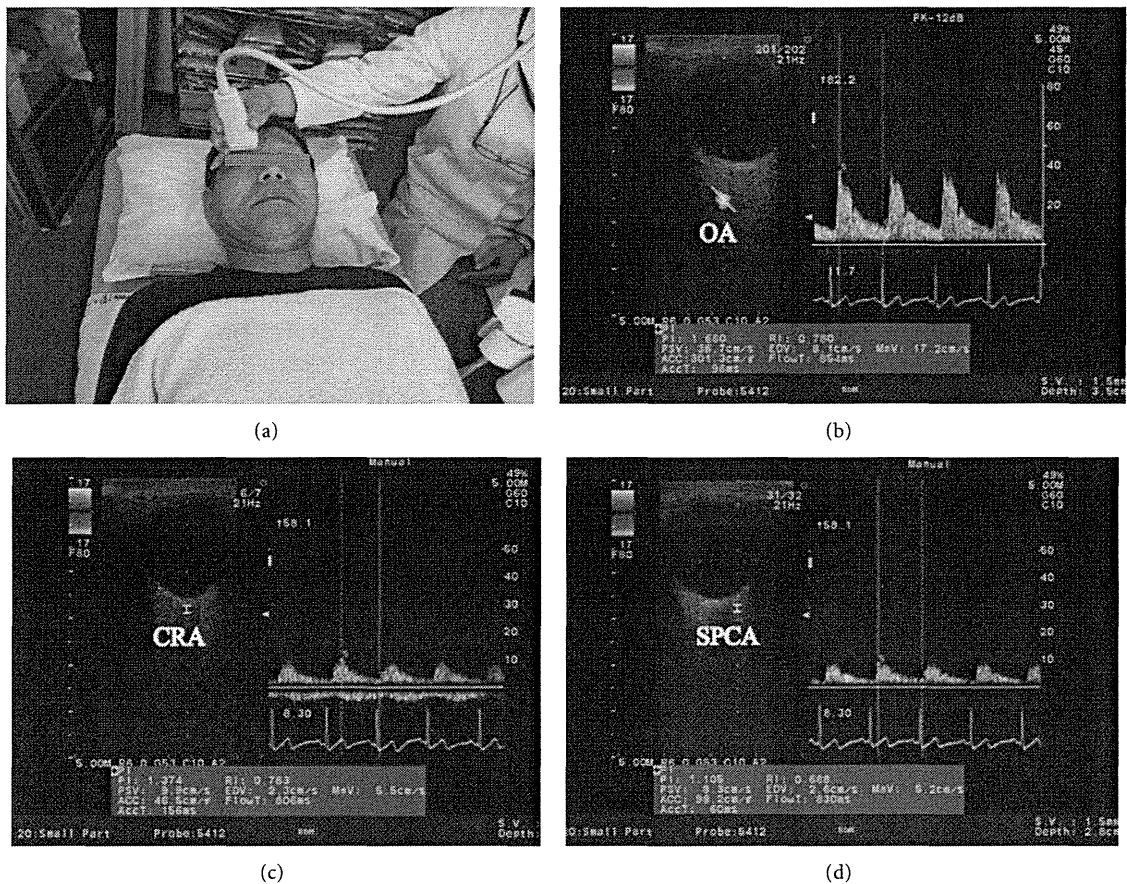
(a) Ultrasound measurement of retrobulbar arteries. 13 MHz liner transducer is attached on the eyelid. Horizontal scans by CDI through the ocular globe showing the (b) ophthalmic artery (OA), (c) central retinal artery (CRA), and (d) temporal short posterior ciliary artery (SPCA). Left: image of the vessel and the position of the artery tracking. Right: Doppler flow and flow velocity (b, c, and d).
